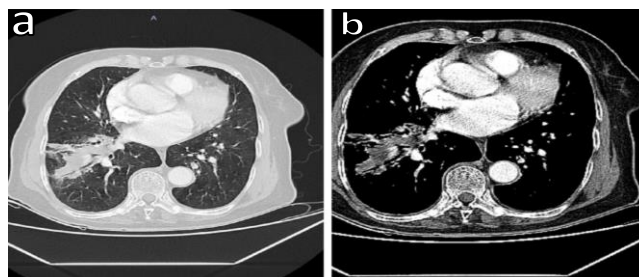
A consolidated area containing air bronchograms observed in the anterobasal right lung lower lobe on thorax CT
